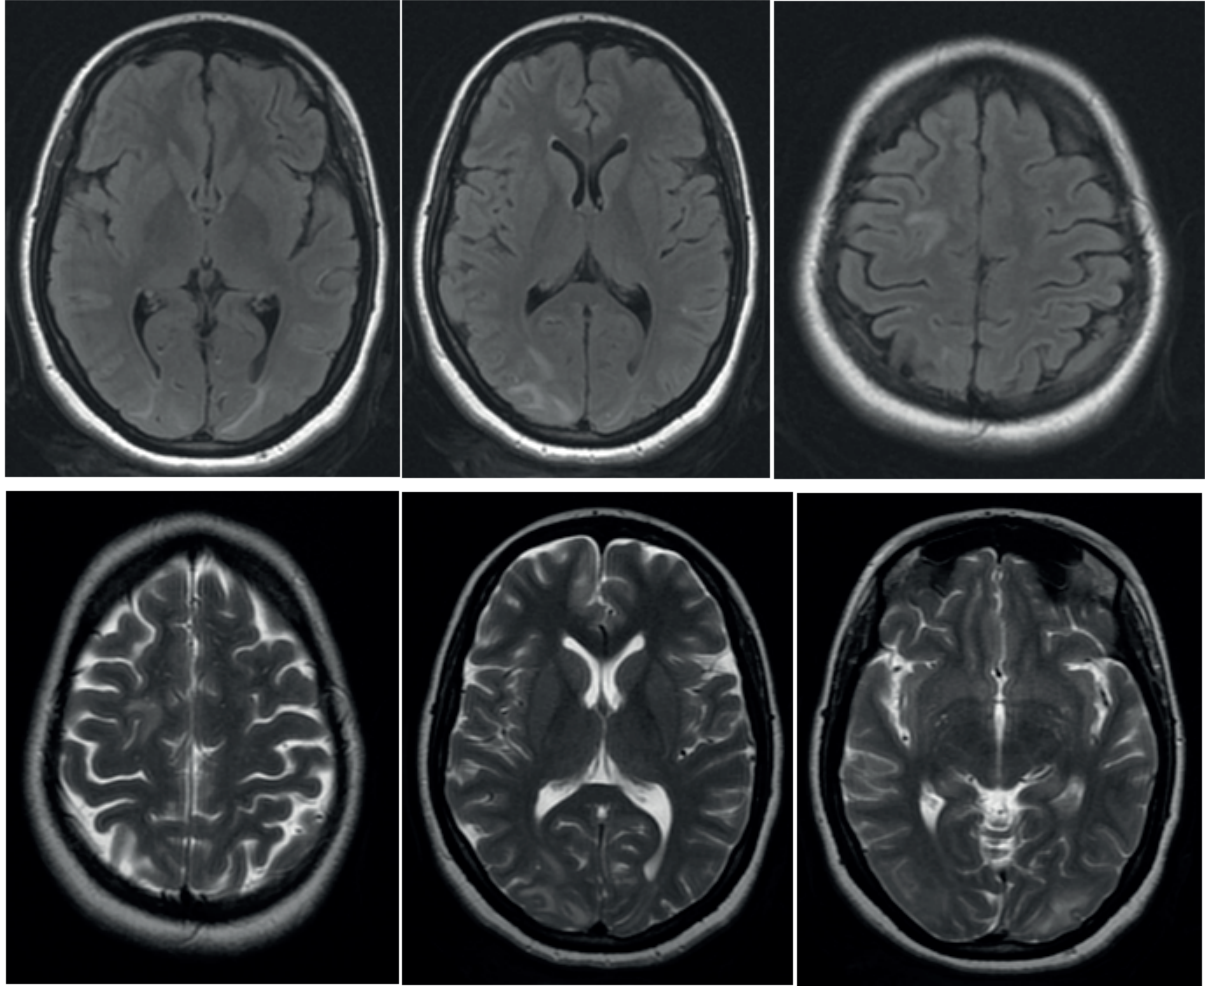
AXIAL T₂ & AXIAL T₂ FLAIR images:
